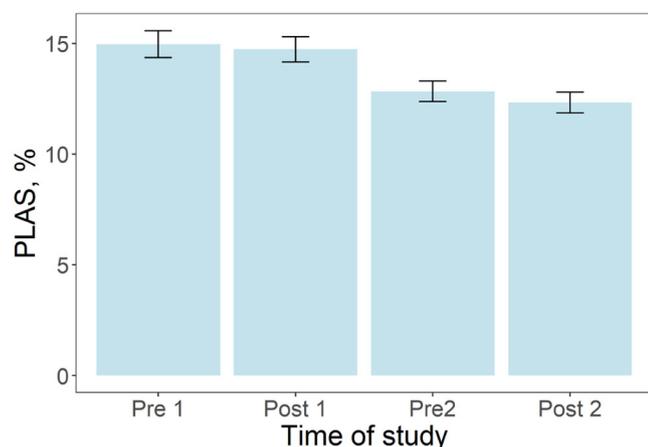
Mean strain (%) of AF patients measured in four MRI studies (same $n = 36$ at each time point). Error bars represent standard error (SE). AF, Atrial Fibrillation; MRI, magnetic resonance imaging.
